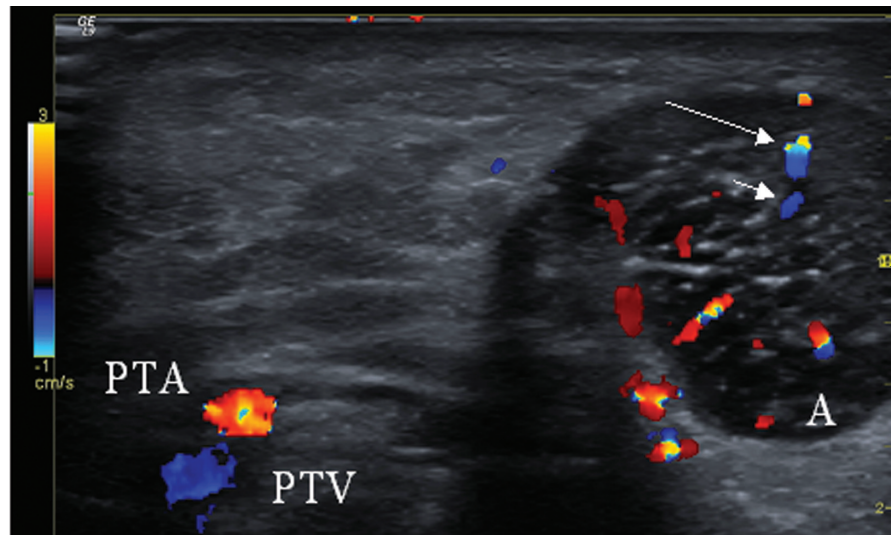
Understanding relative velocities. A transverse scan on the medial side of the right Achilles tendon showing the Achilles tendon (A), the posterior tibial artery (PTA), and posterior tibial vein (PTV). The transducer is tilted slightly cranial in order to improve the Doppler angle to the PTA. The colour bar shows that blood moving downwards in the image is deep blue if slow, and light blue if fast. Likewise, upward movement is deep red if slow, and yellow if fast. If blood moves straight up the signal will alias if the velocity is above 3 cm/s – straight down at 1 cm/s. Since we do not know the insonation angle to any of the vessels in the image we cannot compare velocities between vessels. The vessel indicated by the long arrow has a lighter hue of blue (indicating higher velocity) than the vessel indicated by the short arrow. However, it may in fact be blood moving at a lower velocity but at a better Doppler angle (closer to 0 degrees insonation). It is correct to compare the relative velocities inside the PTA because the whole vessel is probably insonated at the same angle. It is therefore correct to interpret the yellow in the centre as blood moving at a higher velocity than that closest to the wall (red). Actually, at the very centre of the PTA, the signal is aliasing (showing a blue spot in the centre of the yellow).
